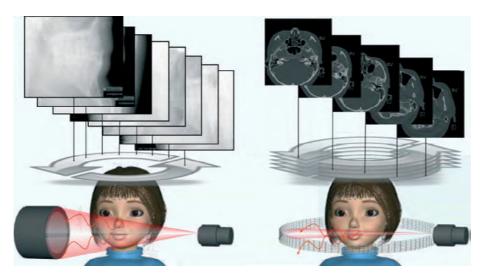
CBCT Image production
